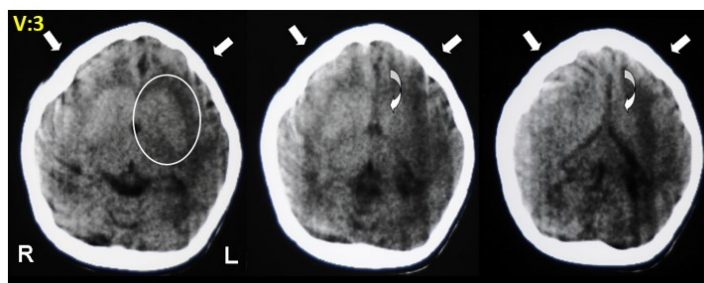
Computed tomography of V:3. Selected axial slices of cranial computed tomography. Notwithstanding compromised image quality, some distinct features can be noted: diminished cranial circumference with symmetrically poorly developed frontal lobes (arrows; also note deformed shape of the skull), poorly confined basal ganglia (oval) with missing delineation of the internal capsule, dysmorphic lateral ventricles (curved arrows; slit-like frontal horns), and infratentorial abnormality with hypoplasia of the vermis cerebelli (images not shown) (figure and text reproduced from (Khan, Rupp et al. 2014) with permission of Human Molecular Genetics).
